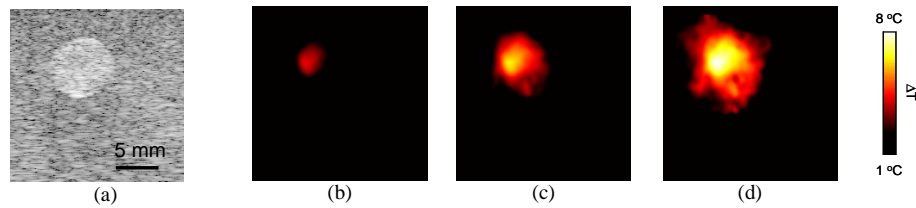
(a) Ultrasound image of the hyperechoic inclusion with embedded photoabsorbers. (b-d) Thermal images recorded at 30, 60 and 180 seconds of laser irradiation, respectively. All images cover a 20 mm by 20 mm region.
